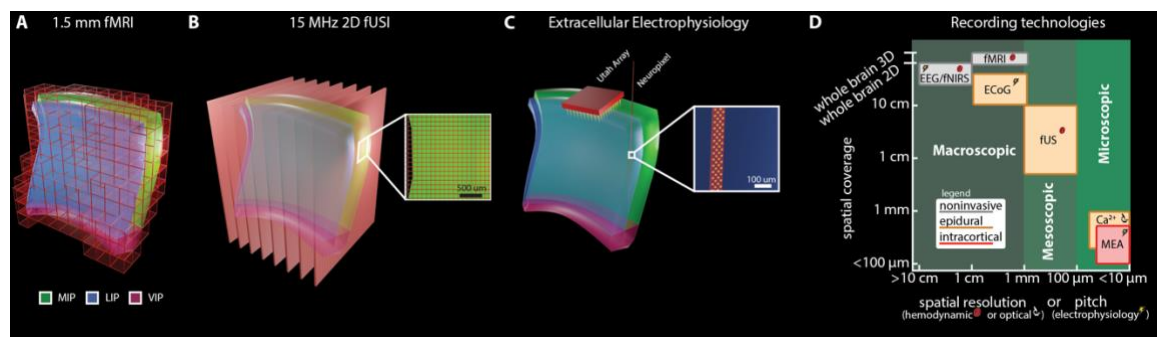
Functional ultrasound enables mesoscopic imaging of neural populations
